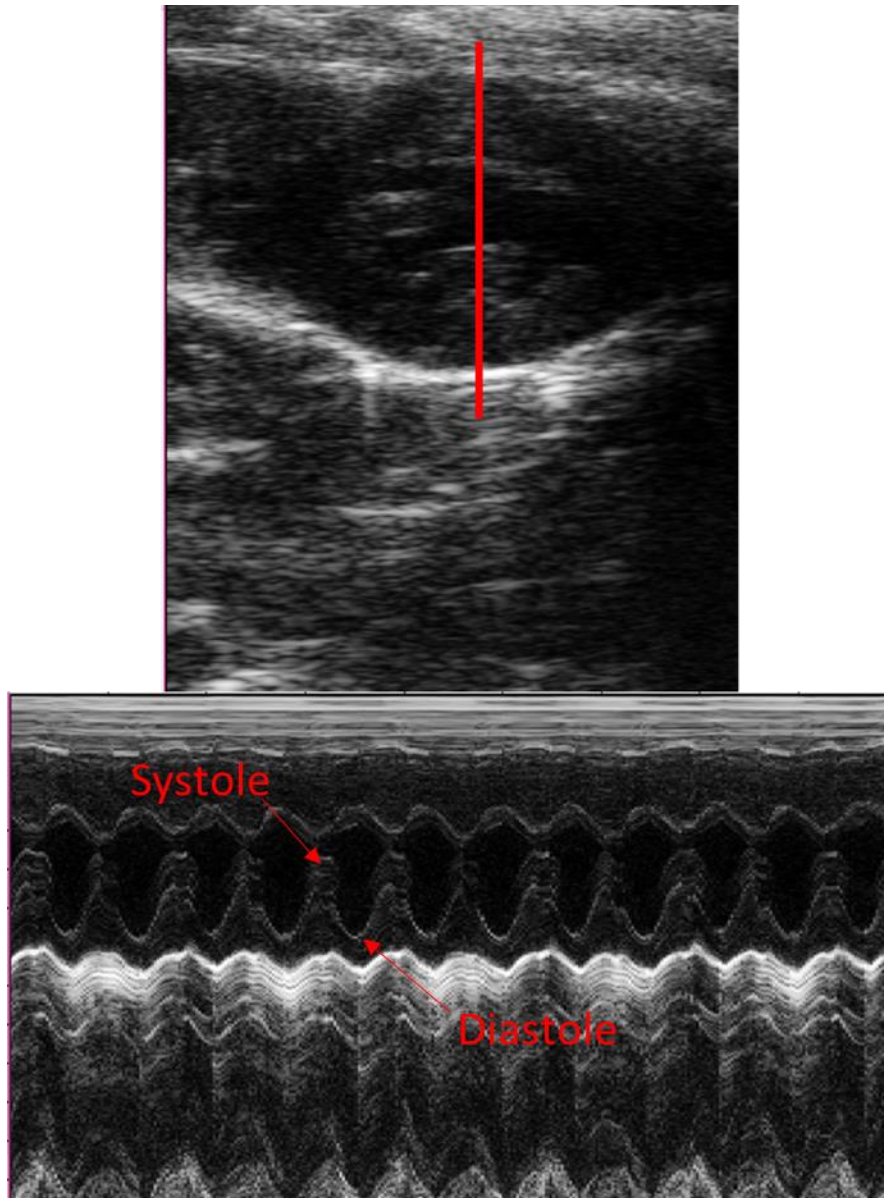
Good Quality Echocardiography Images that meet Selection Criteria (Echocardiography 2018)
